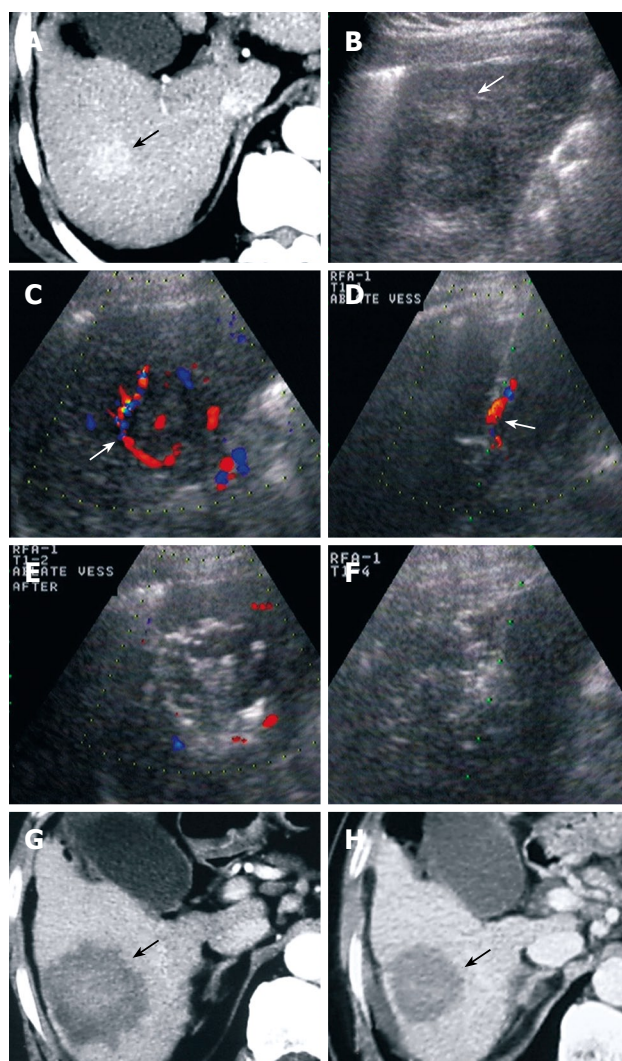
A 65-year-old man with cirrhosis and Child-Pugh class A liver function. An HCC lesion was diagnosed during regular US examination. A: CT showed a tumor with a size of 3.2 cm × 3.0 cm in the right liver lobe; B: US showed a tumor (arrow) of 4.3 cm × 3.3 cm 3 mo later; C: CDFI showed blood flow into and around the tumor with a velocity of 56.7 cm/s; D: CDFI-guided PAA at the area where the feeding artery entered the tumor (arrow), to block the tumor blood supply; E: After PAA, CDFI showed that the previous feeding artery disappeared and no flow signal within HCC; F: After PAA, RFA was performed in the rest of the tumor; G: Contrast-enhanced CT (1 mo after treatment) showed an ablated area covering the previous tumor, without enhancement; H: Contrast CT (6 mo after treatment) showed no enhancement of the ablated area. The patient has survived more than 10 mo without tumor.
